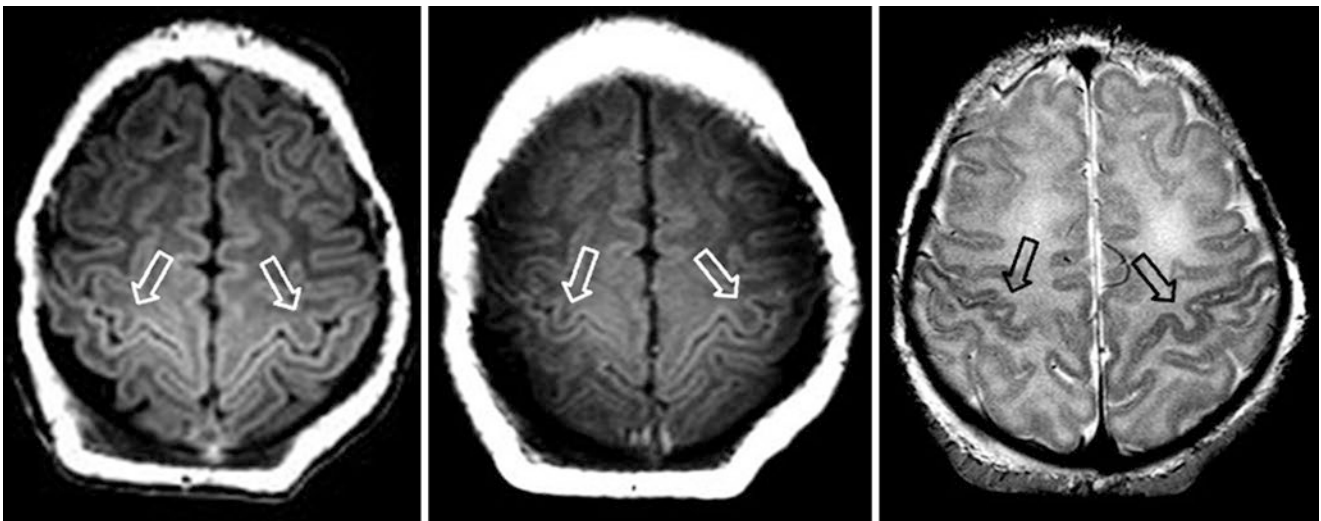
A 3-day-old term neonate had a normal 3T MRI with GE T1WI (left), SE T1WI (middle), and SE T2WI (right). The PRC (open arrows) appears slightly bright on GE T1WI, and slightly darker than the remainder of the cortices on SE T2WI
